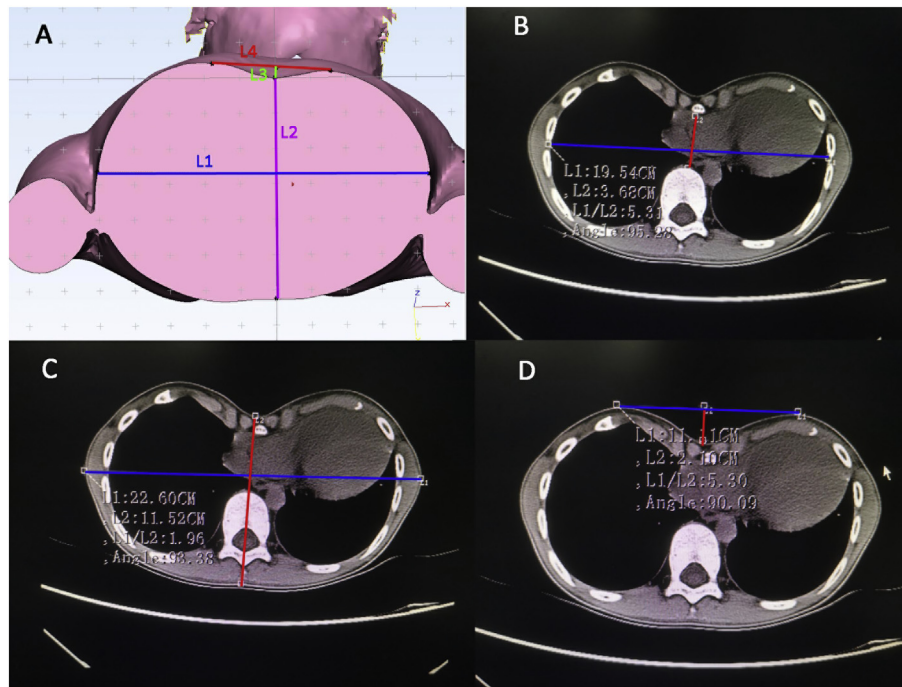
Measurements in Materialise 3-Matic and institutional PACS system with images obtained from body surface scanning and CT, respectively. Images shown are cross sectional ones through the deepest depression. A: L1: the lateral external distance of the chest; L2: the distance between the external deepest point in the front chest and the external spinous process; L4: the distance between the highest points on each side of the front chest; L3: the shortest vertical distance between external deepest point and L4. B: L1: the internal lateral chest wall distance; L2: the distance between the internal deepest point in the front chest and the anterior surface of the vertebrae; C: L1: the external lateral chest wall distance; L2: the distance between the external deepest point in the front chest and the posterior body surface projection of spinous process; D: L1: the distance between the highest points on each side of the front chest; L2: the distance between the external deepest point in the front chest and L1.
